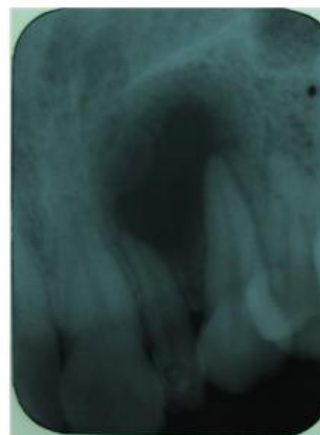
Retro-alveolar X-ray showing a radiolucent image between 22 and 23
